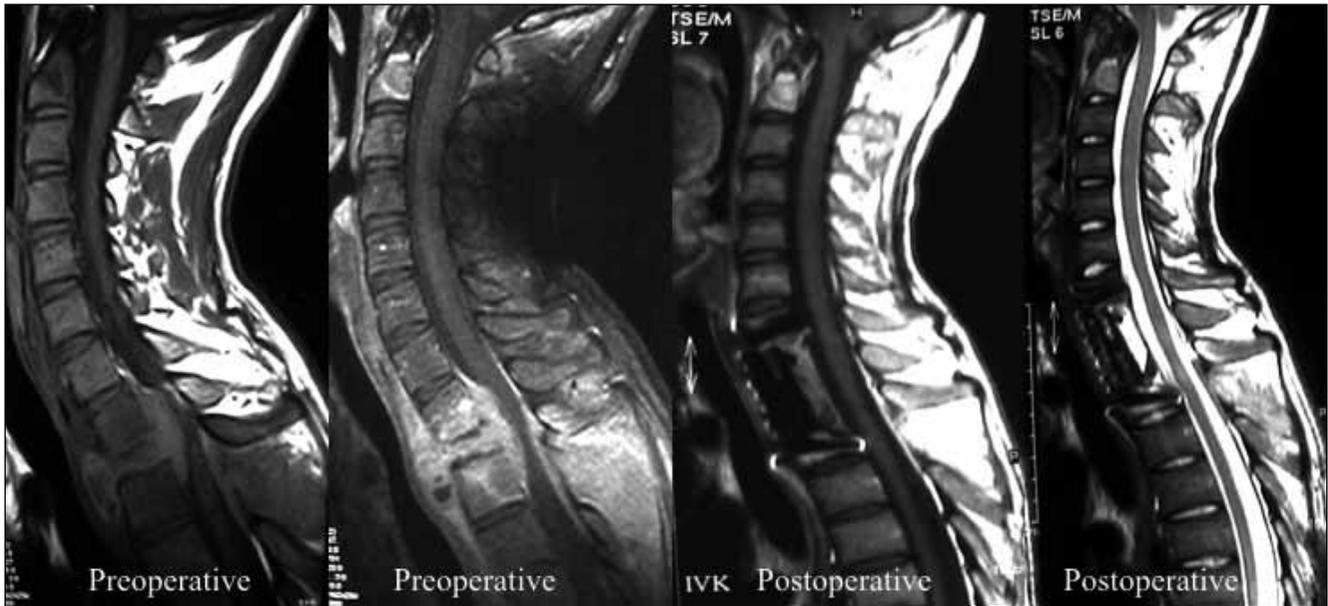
(Case 2) 21-year-old female had tuberculosis osteomyelitis and her ASIA score was A. Preoperative MRI revealed thoracic one and two osteomyelitis (on the left side). Thoracic one, two and partial upper corpectomy and decompression was performed. Fibular allograft was used for reconstruction. Cervicothoracic alignment was maintained after the surgery (on the right side). In the fifth year follow-up, the patient’s ASIA score was D.
